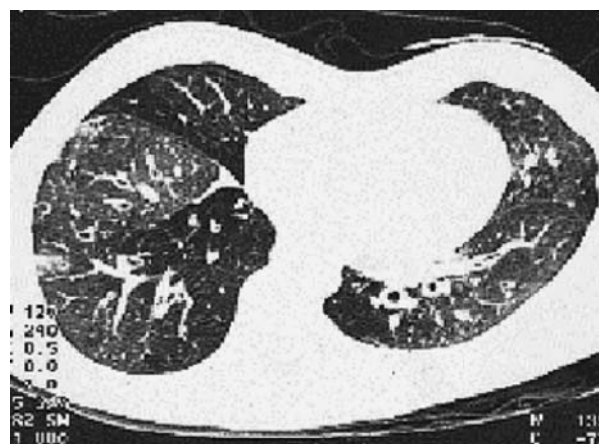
Chest CT scan with moderate abnormalities.
